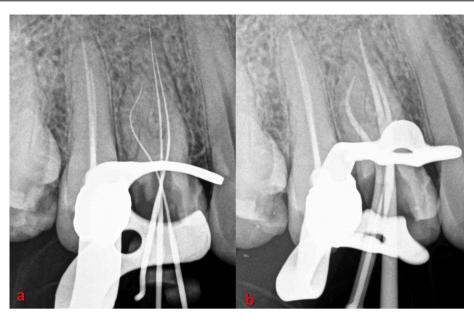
a. Working length determination by radiography; b. Master cone confirmation by radiography.
